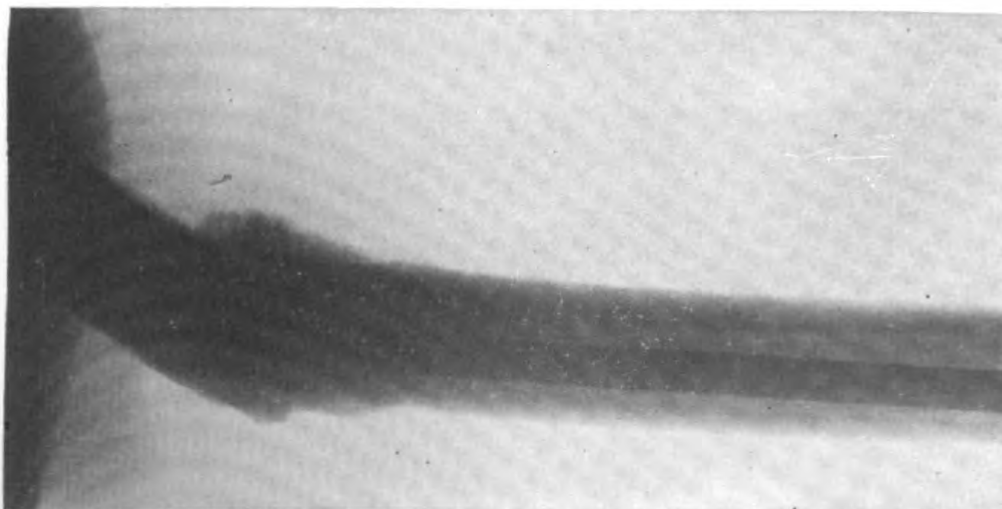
Case 3. Postoperative anterior-posterior x-ray at 5 months.
